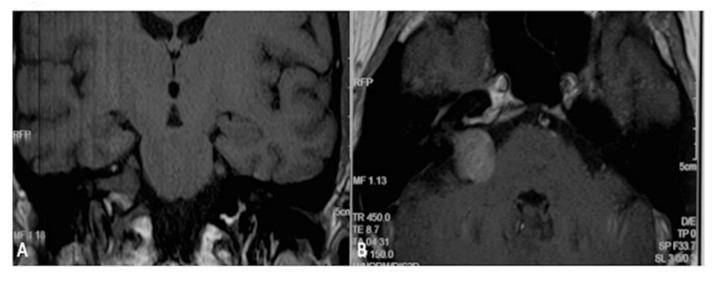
MRI of the cerebellopontine angle (CPA) on coronal T1W (A) and axial T1W post-contrast (B). An enhancing lesion in the right CPA extends into the right internal auditory canal with an expansion of the acoustic meatus consistent with acoustic neuroma.
